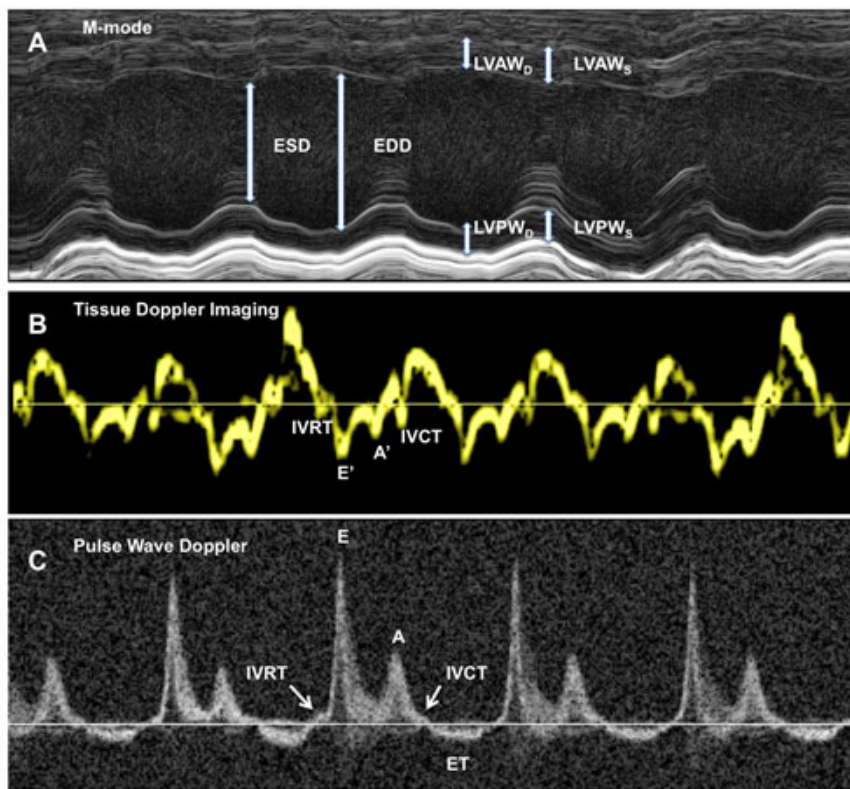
Acquisition and Quantification of Echocardiography and Doppler Data. This figure contains representative images of acquired data corresponding to the 2D echocardiography images presented in Figure 2. (A) M-mode tracing with lines indicating end-systolic (ESD) and end-diastolic diameters (EDD). LVAW_D/S, left ventricular anterior wall thickness (diastole/ systole); LVPW_D/S, left ventricular posterior wall thickness (diastole/ systole). (B) Representative tracings for tissue Doppler imaging of the LV posterior wall. IVRT, isovolumic relaxation time; IVCT, isovolumic contraction time. The E' wave corresponds to the motion of the mitral annulus during early diastolic filling of the LV, and the A' wave originates from atrial systole during late filling of the LV. S' represent systolic velocity. (C) Pulse wave Doppler recording of mitral valve leaflet tips provides mitral inflow velocity patterns from which early diastolic velocity (E), late diastolic velocity with diastolic contraction (A), and the E/A ratio can be derived. The IVRT is also a useful variable to characterize diastolic function and filling pressures. ET indicates ejection time.
